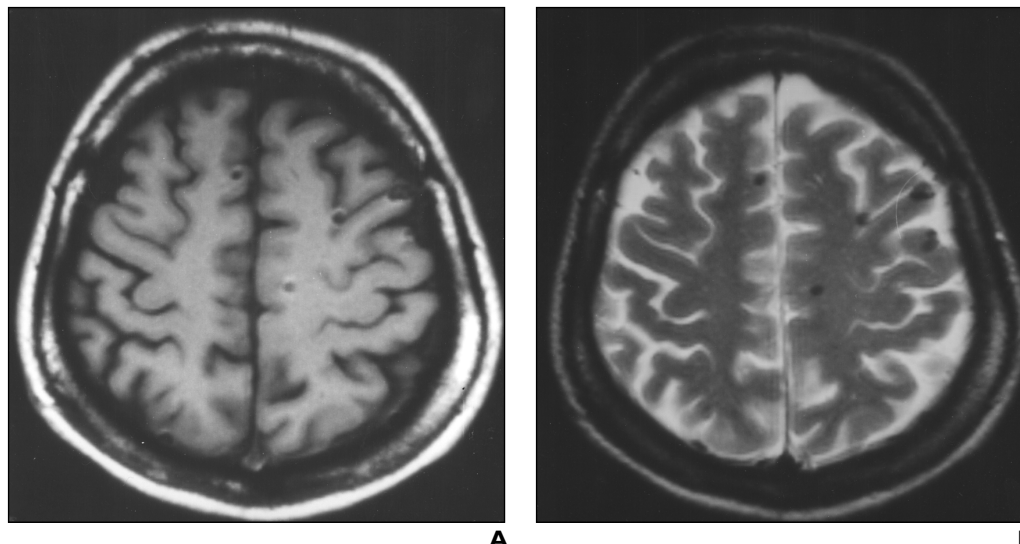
40-year-old woman in the later phase of acute Nipah encephalitis. A and B, T1-weighted (A) and T2-weighted (B) spin-echo MR images show discrete round lesions with MR signal of old blood products.
